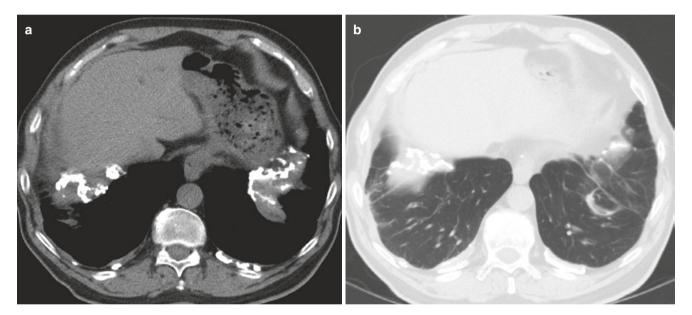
Linear opacities in asbestosis. (a) Axial CT image in the soft-tissue window shows calcified pleural plaques. (b) CT image in lung windows shows subpleural linear opacities suggesting early parenchymal involvement
